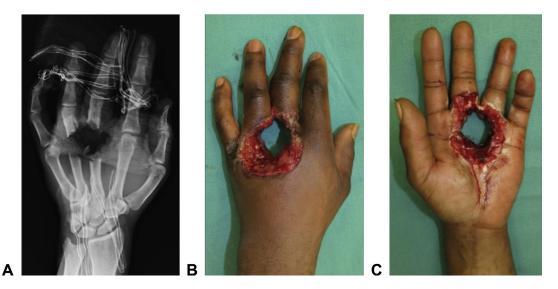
Preoperative data. A Preoperative x-ray of the left hand demonstrates traumatic loss of the ring and middle finger MCP joints. B, C Intraoperative photographs represent the extent of soft tissue and joint loss.
